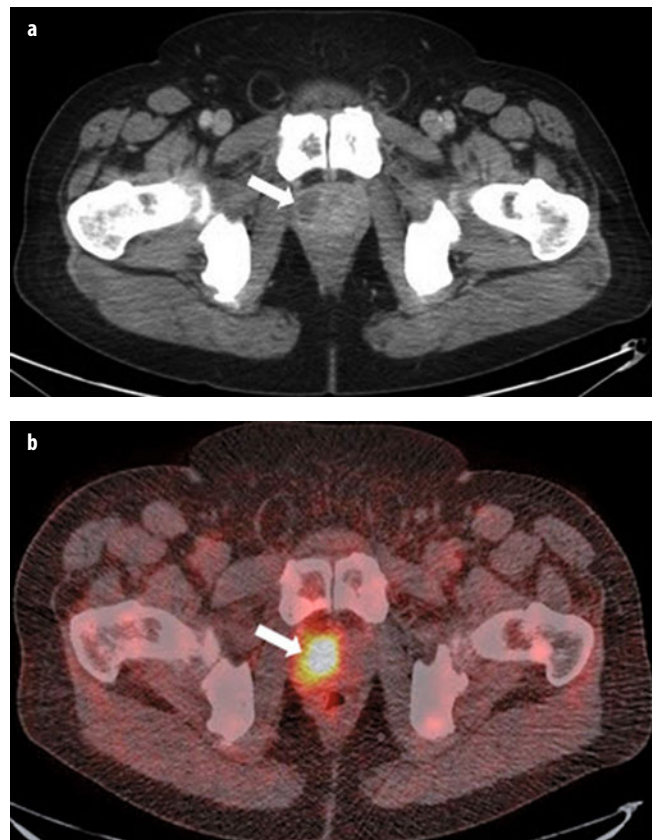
a, b. a Axial computed tomography (CT) and b fused [^{18}F]-fluorodeoxyglucose (FDG) positron emission tomography computed tomography (PET/CT) images in a patient who had undergone transrectal ultrasound-guided prostate biopsy a few days earlier demonstrate abnormal FDG uptake in a prostatic abscess (arrows)
